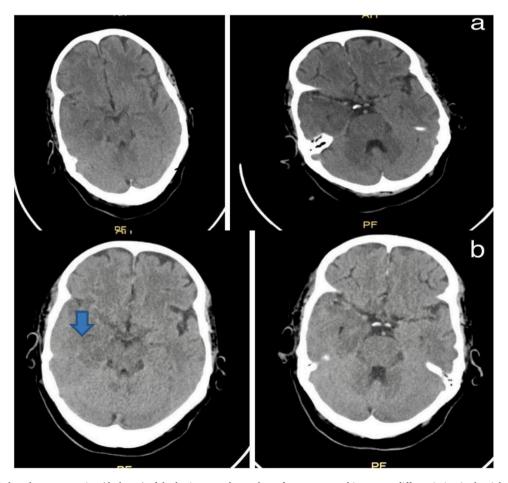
Axial Brain CT show hypoattenuation (darkness) of the brain parenchyma; loss of gray matter-white matter differentiation in the right fronto-temporal area. (a) Post admission day-1 (b) post admission day-2.
